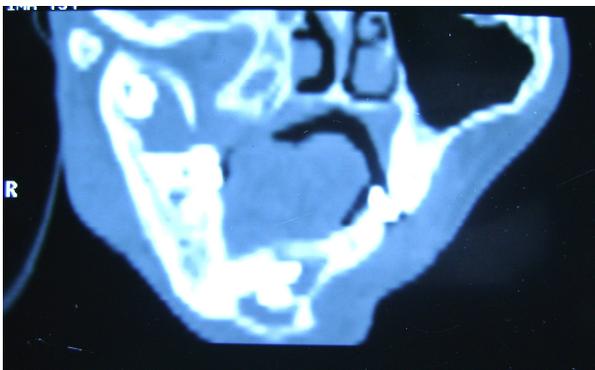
CT Coronal Section Showing Impacted Third Molar Surrounded By Cystic Radiolucency
